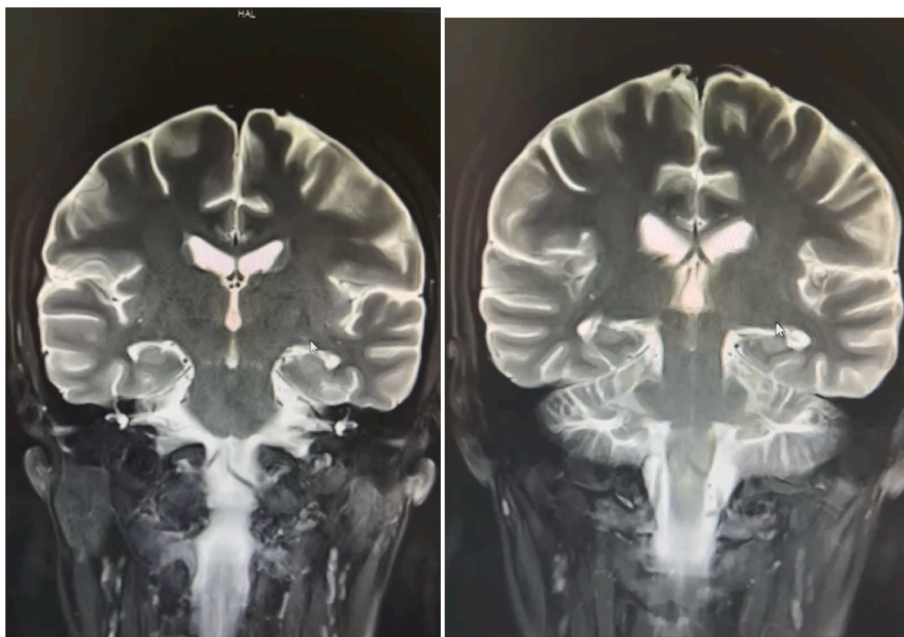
Brain magnetic resonance imaging showing mild atrophy in the bilateral hippocampal on March 25, 2023 (Illness Day Over 2 months).
